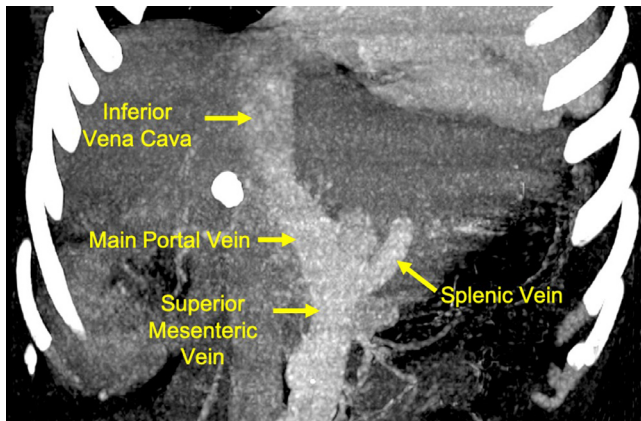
Congenital portosystemic shunts are characterized by the absence of the intrahepatic portal vein. Coronal contrast-enhanced CT maximum intensity projection shows the splenic vein and superior mesenteric vein coming together to form a short segment of the main portal vein, which then forms a broad confluence with the inferior vena cava. No intrahepatic portal vein is identified. Note the hyperdense region in segment 4A where a biopsy-confirmed hepatocellular carcinoma was noted and underwent combination transarterial chemoembolization and microwave ablation therapy
